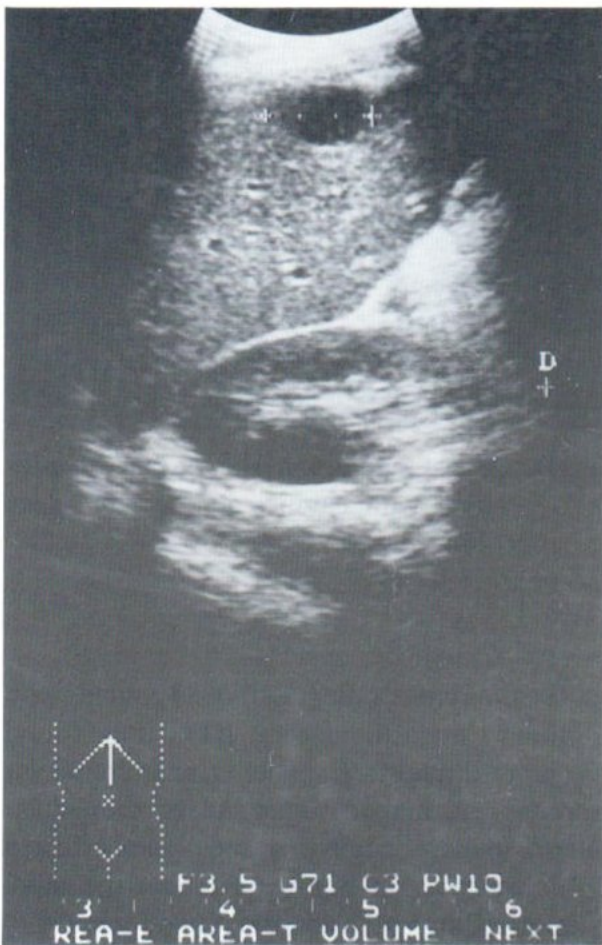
Longitudinal ultrasound image of the liver shows a hypoechoic mass (+...+) in the right liver lobe.
